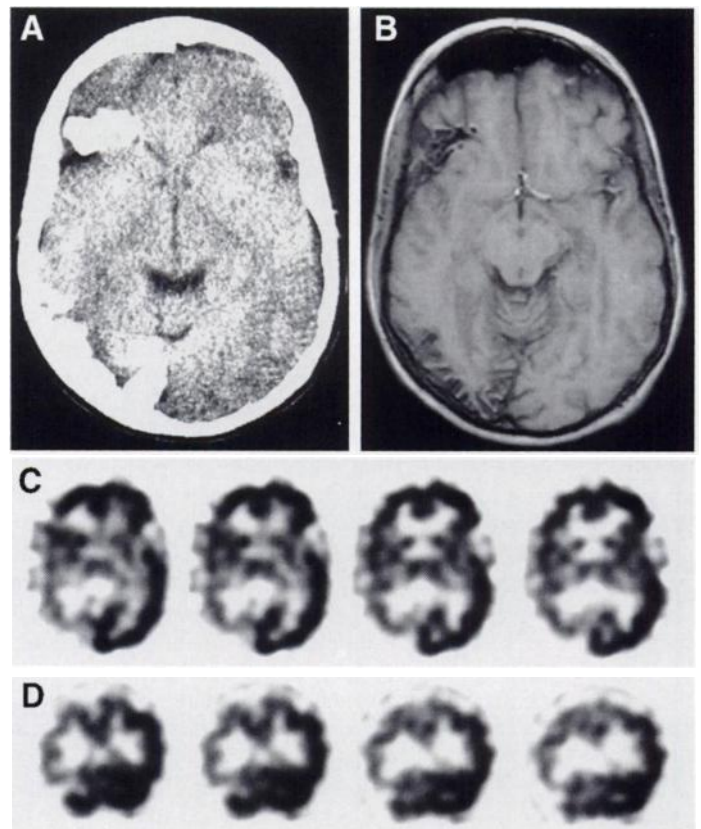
Nonenhanced CT (A) and axial T1-weighted MRI (B) show calcifications in the posterior right frontal, temporal and parieto-occipital cortex. Transverse (C) and coronal (D) ^{99m}Tc -HMPAO SPECT reveal diminished uptake in the right occipital, parietal and posterior frontal cortex.
